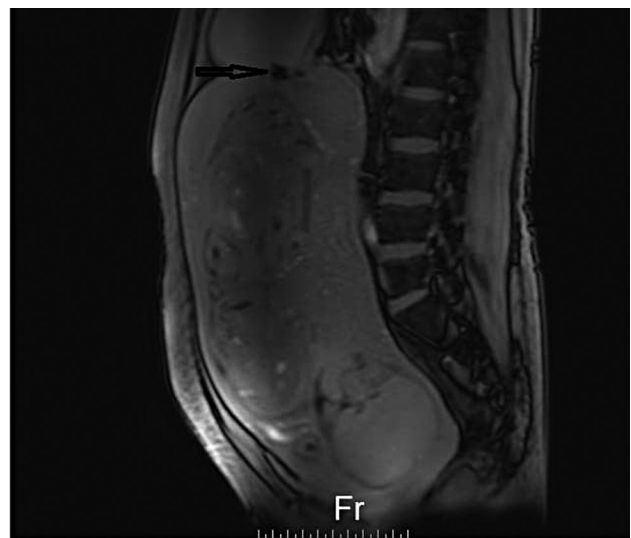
A 9.7×7.9 mm² rupture of the left uterine horn by MRI (arrows).
